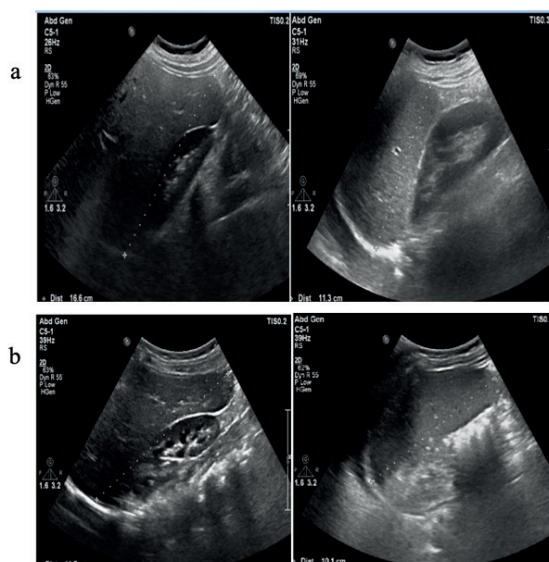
Ultrasound images showing the maximum lengths of patients' (a: index case, b: sibling) liver and spleen.
